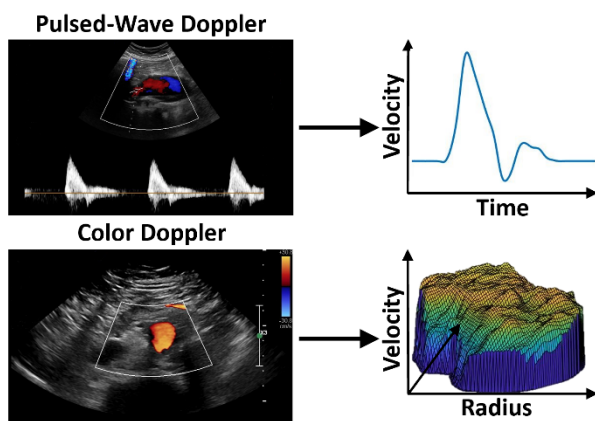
pulsed-wave (top) and color (bottom) Doppler acquisitions used to extract the velocity profile over the time and cross-section, respectively.
